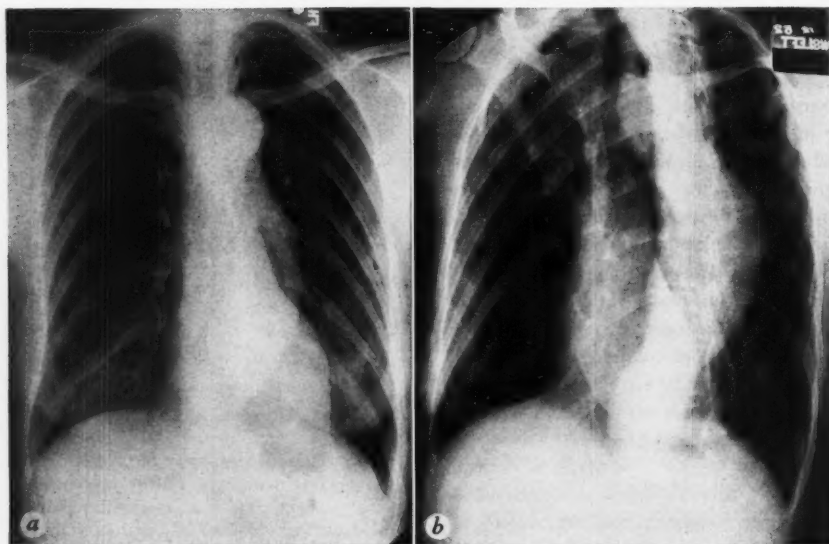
a* and *b*. Anteroposterior and left oblique roentgenograms of the chest of a woman aged 32, in 1951, who gave a history that in the last month of pregnancy she experienced severe substernal and back pain that was not alleviated by morphine. Delivery of a live baby occurred two and one-half hours later but the patient was unaware of labor pains. The postpartum course was complicated by heart failure which responded to therapy. The blood pressure was 150/80. The home physician reported that the patient was still living in May, 1955, that she was doing her own housework and that the roentgenographic appearance of the thorax was not essentially different from that of 1952 as shown here.
